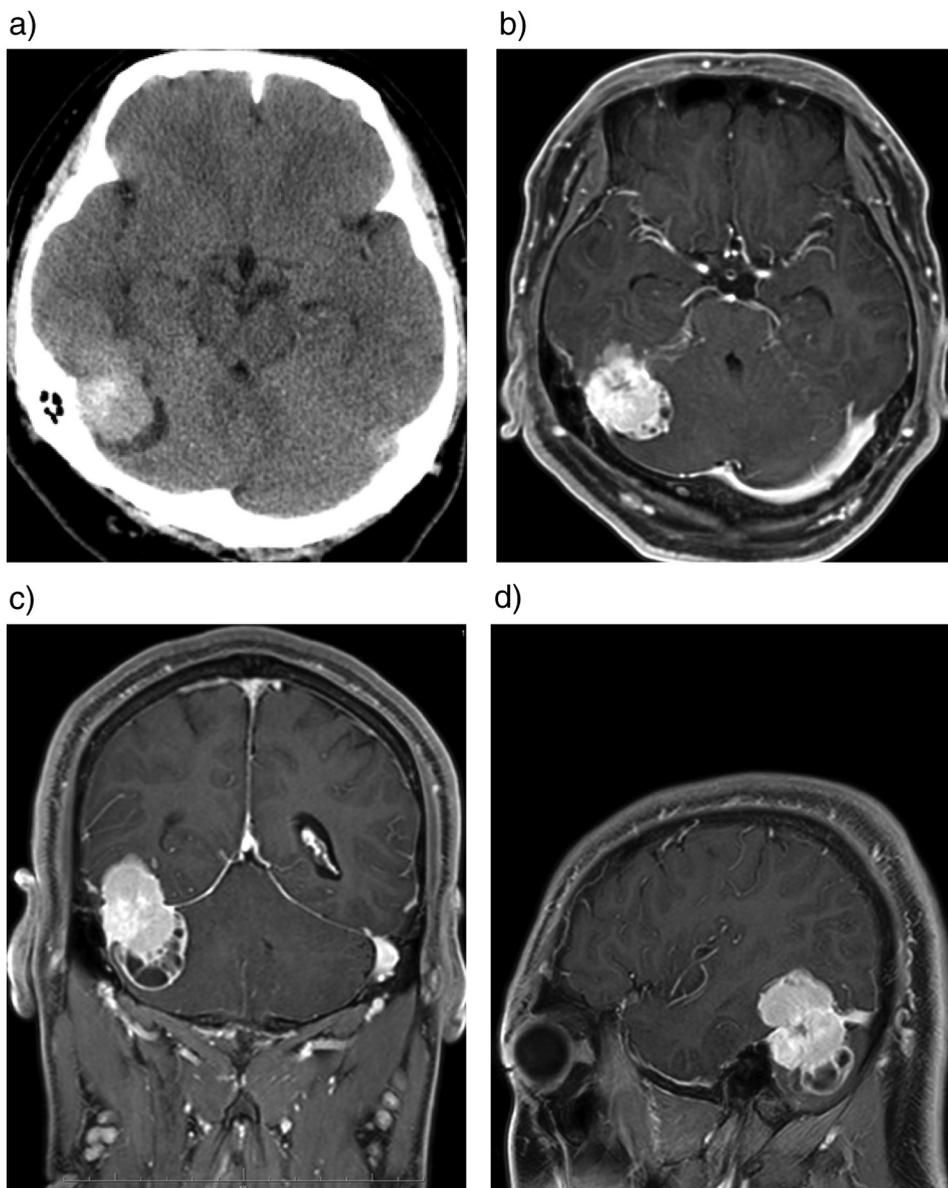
Computed tomography showing a high-density mass around the right cerebellar tentorium (A). Gadolinium-enhanced T1-weighted magnetic resonance imaging showing a well-enhanced mass around the right cerebellar tentorium (B–D).
